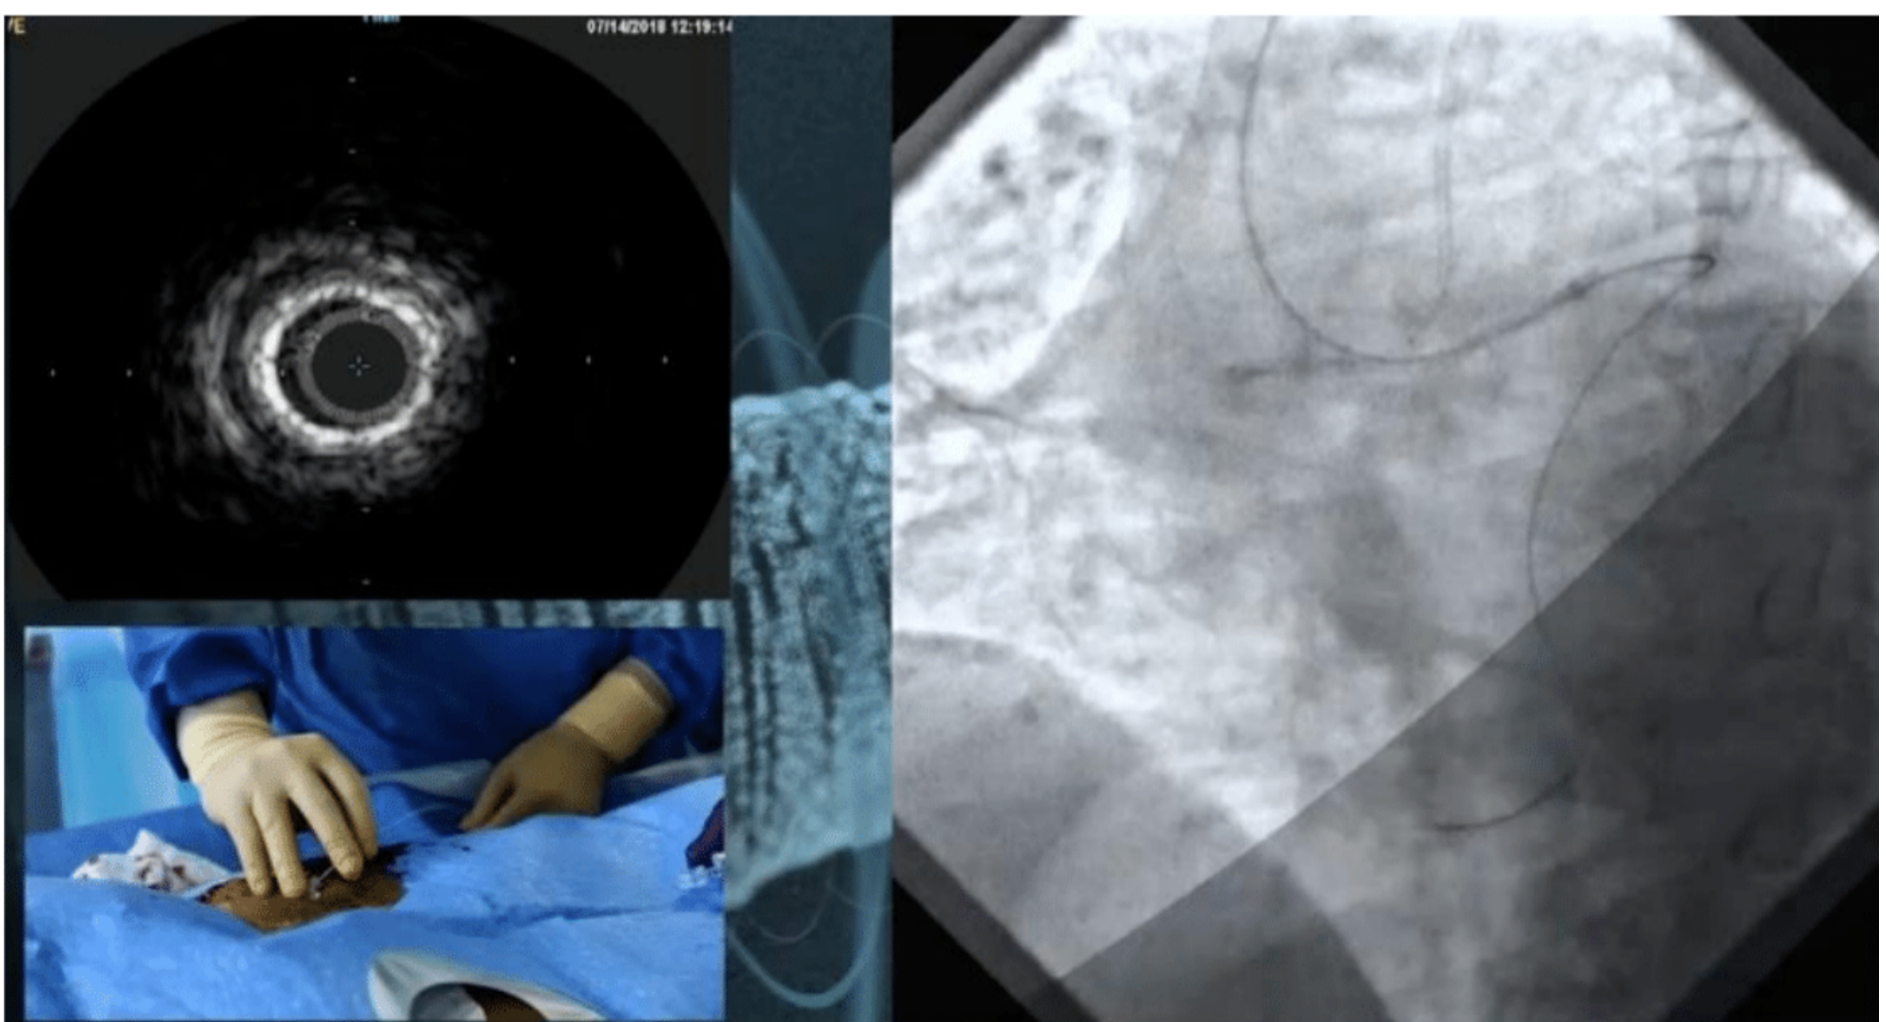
Four specific converters allow simultaneous streaming of video data from angiography, hemodynamic monitoring, high-definition intravascular ultrasound (IVUS), echocardiography, and the local personal computer
